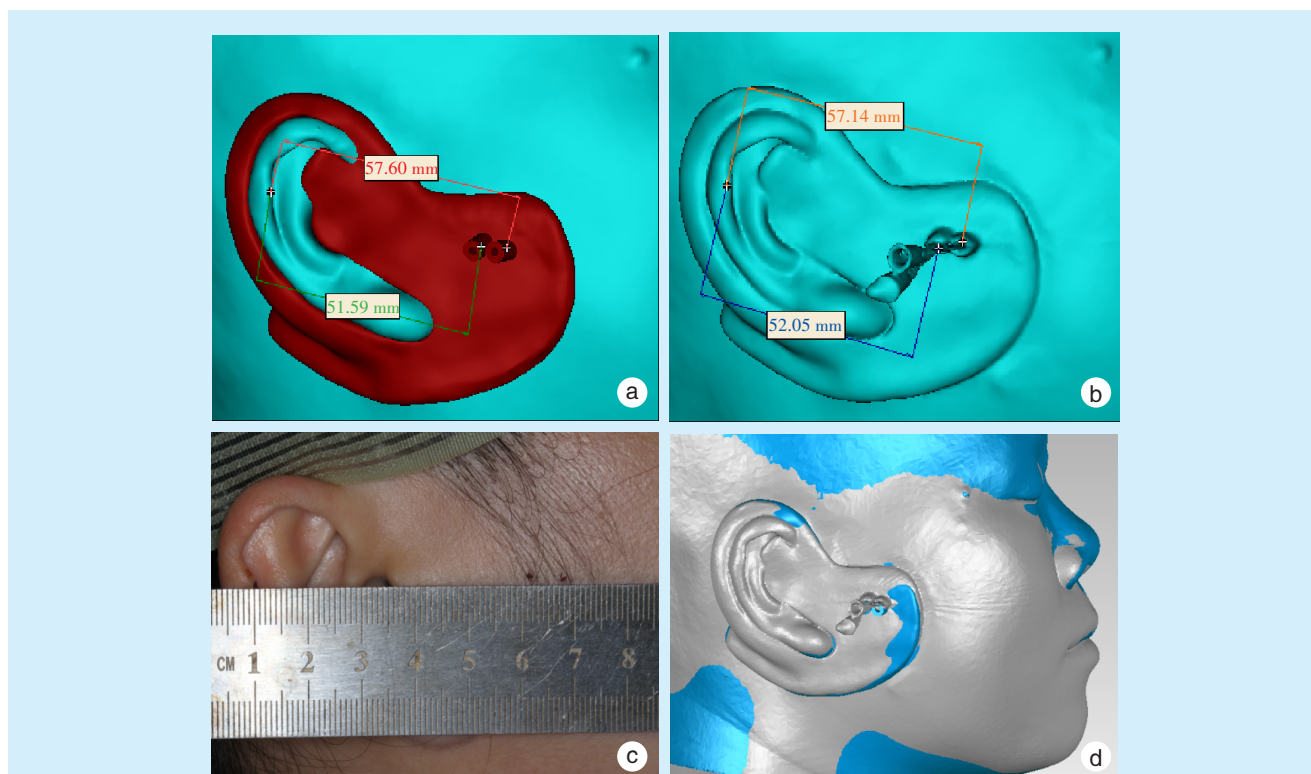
The CT-guided navigation guide plate for targeting lateral pterygoid muscle target has good stability, retention force, and repeatability
